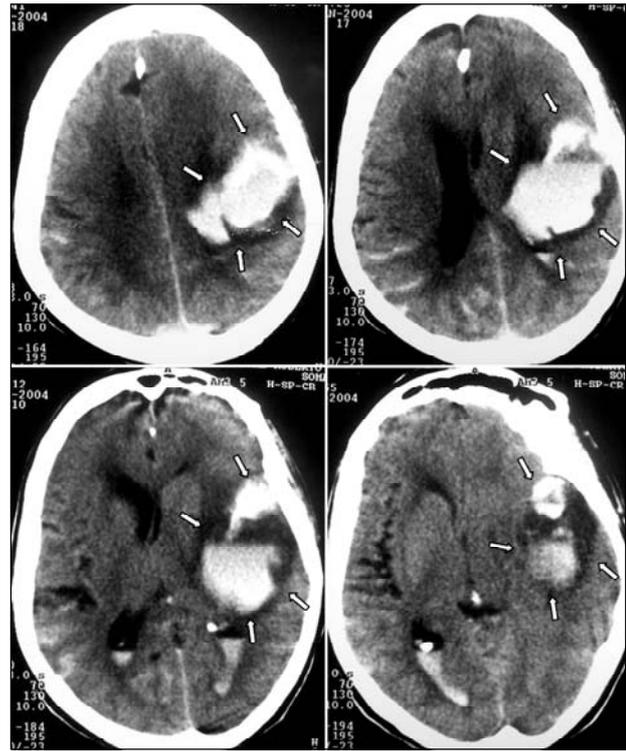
CT scans of the head on the first hospital day showing extensive hematoma in the left temporo-parietal lobe with ventricular flooding and perilesional edema.
